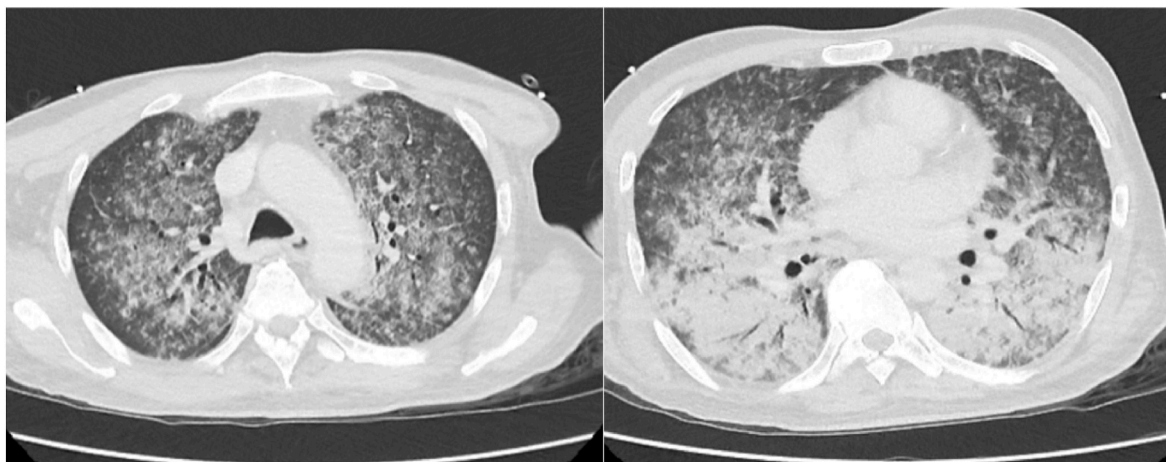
CT scan of chest showing bilateral ground glass changes and consolidation.
